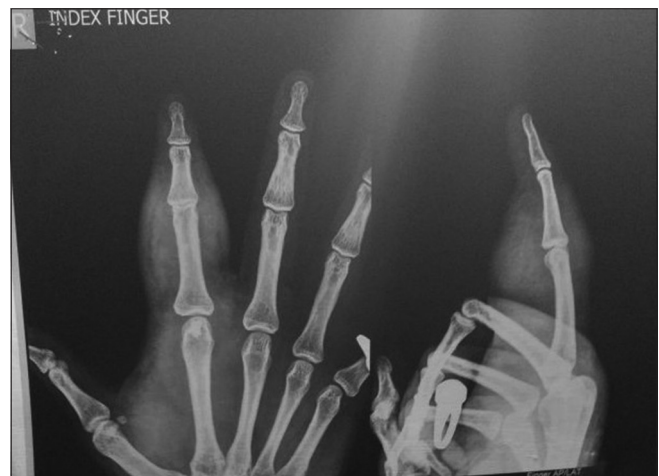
Pre-operative radiograph of the affected finger (right index)
